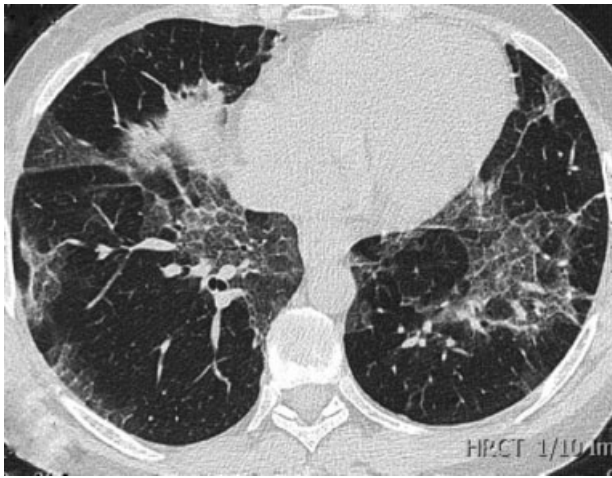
HRCT findings of nonspecific interstitial pneumonia. Patchy areas of ground glass opacities with interlobular septal thickening and reticulation involving bilateral lower lobes. HRCT, high-resolution computed tomography.
